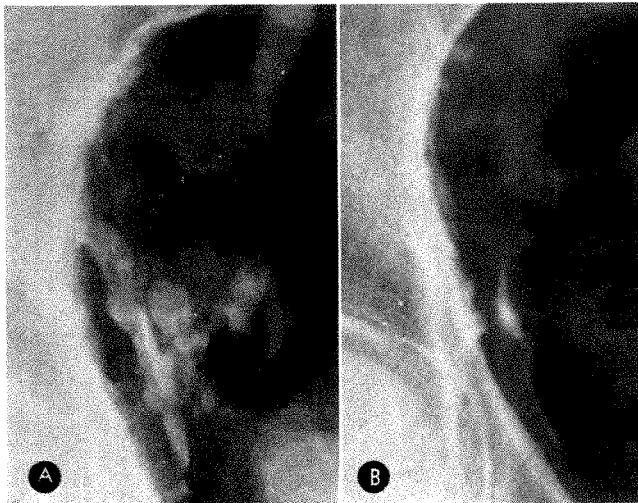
Radiographs of two patients showing periosteal thickening. Note globular clumps and relation of calcification to ureters (A).
